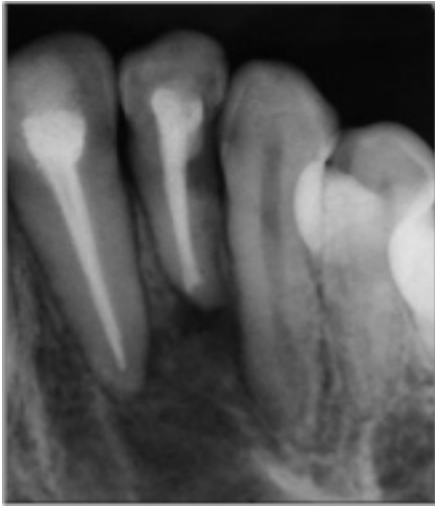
Pre operative IOPA indicates resolved periapical lesion with interdenal bone loss in the coronal 1/3rd area.
